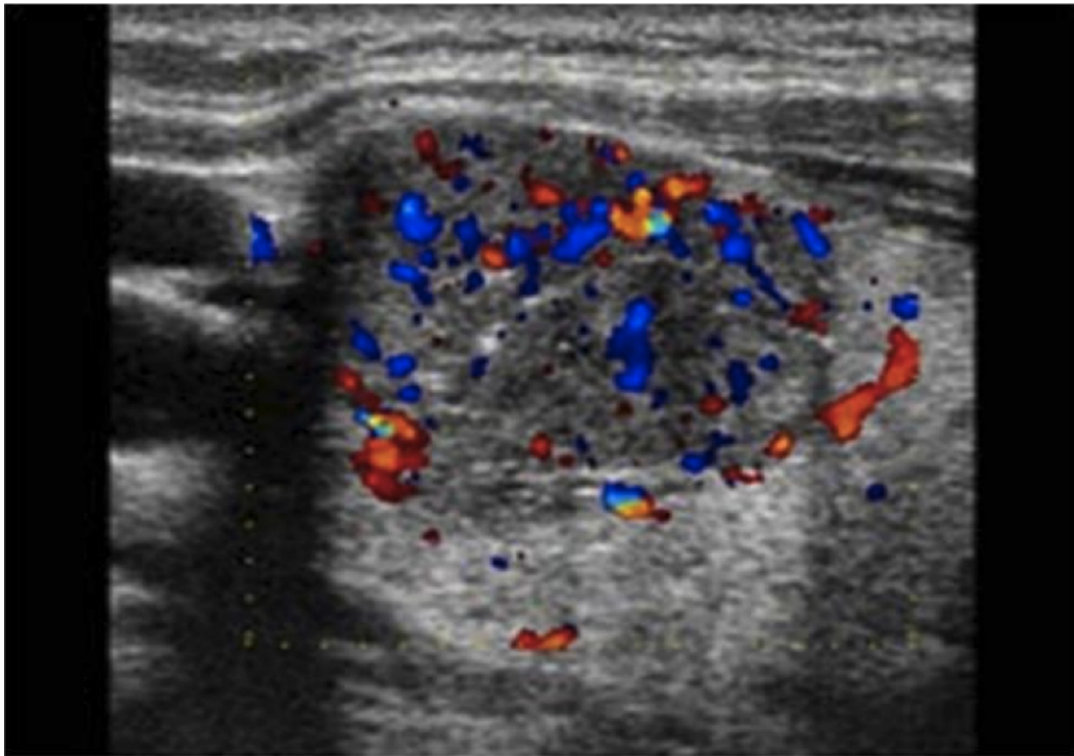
Ultrasound image of a malignant thyroid nodule, showing a hyper-vascularized thyroid nodule, with intranodular vascularization.
